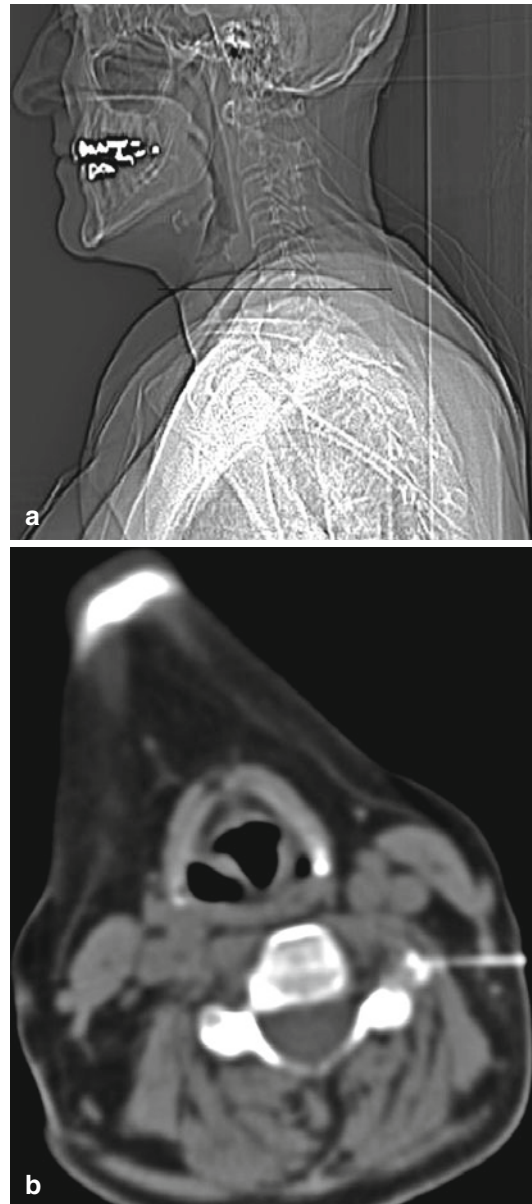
CT-guided periradicular therapy (axial CT scan (b) of the cervical spine level C6 left (a, Sagittal CT-topogram))
